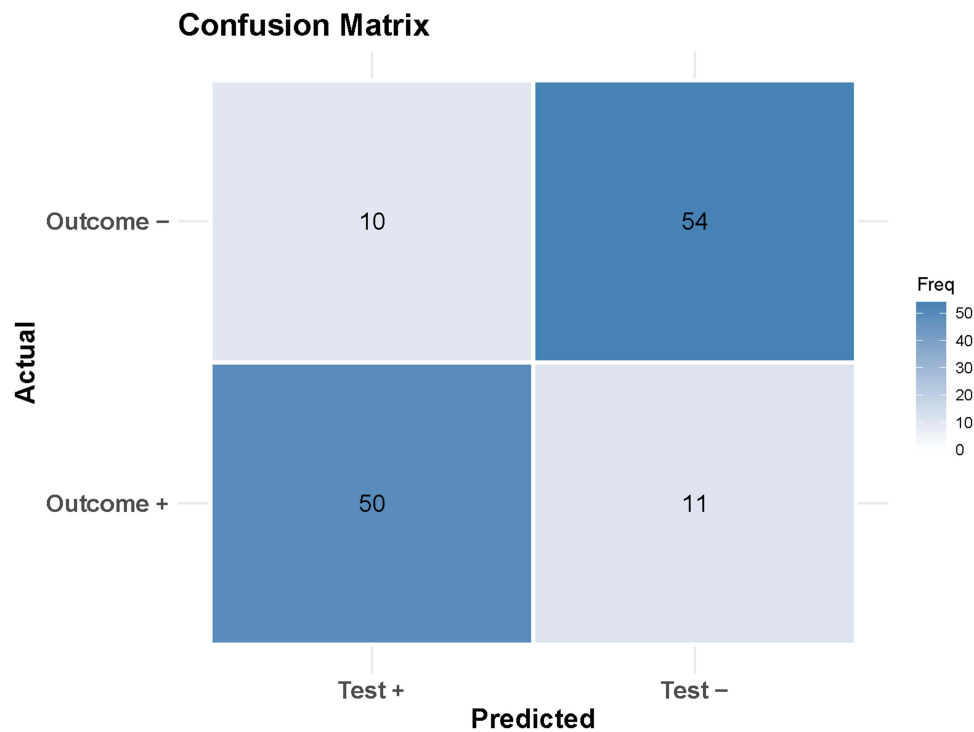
Confusion matrix for the constructed multi-modality ultrasound model.
